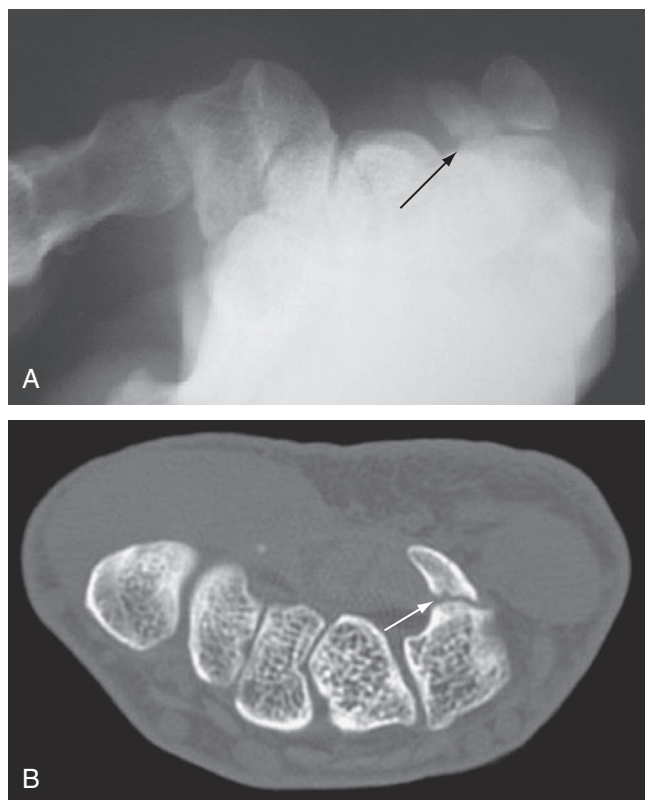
A, Carpal tunnel view radiograph showing a hamate hook fracture (arrow). B, Coronal computed tomography scan showing the same hamate hook fracture.
